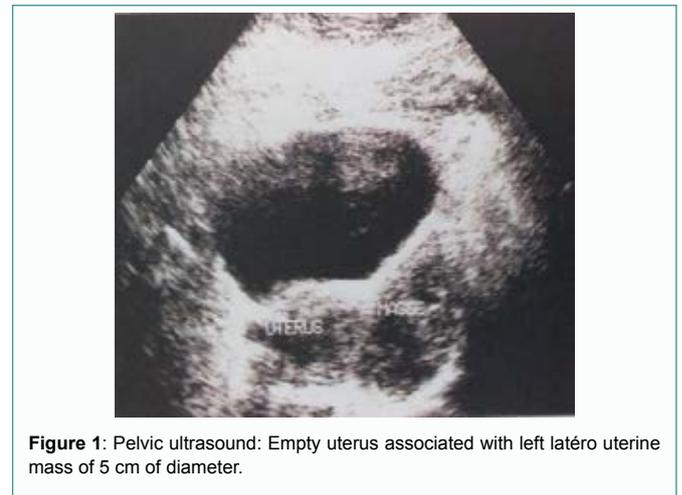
Pelvic ultrasound: Empty uterus associated with left latéro uterine mass of 5 cm of diameter.
